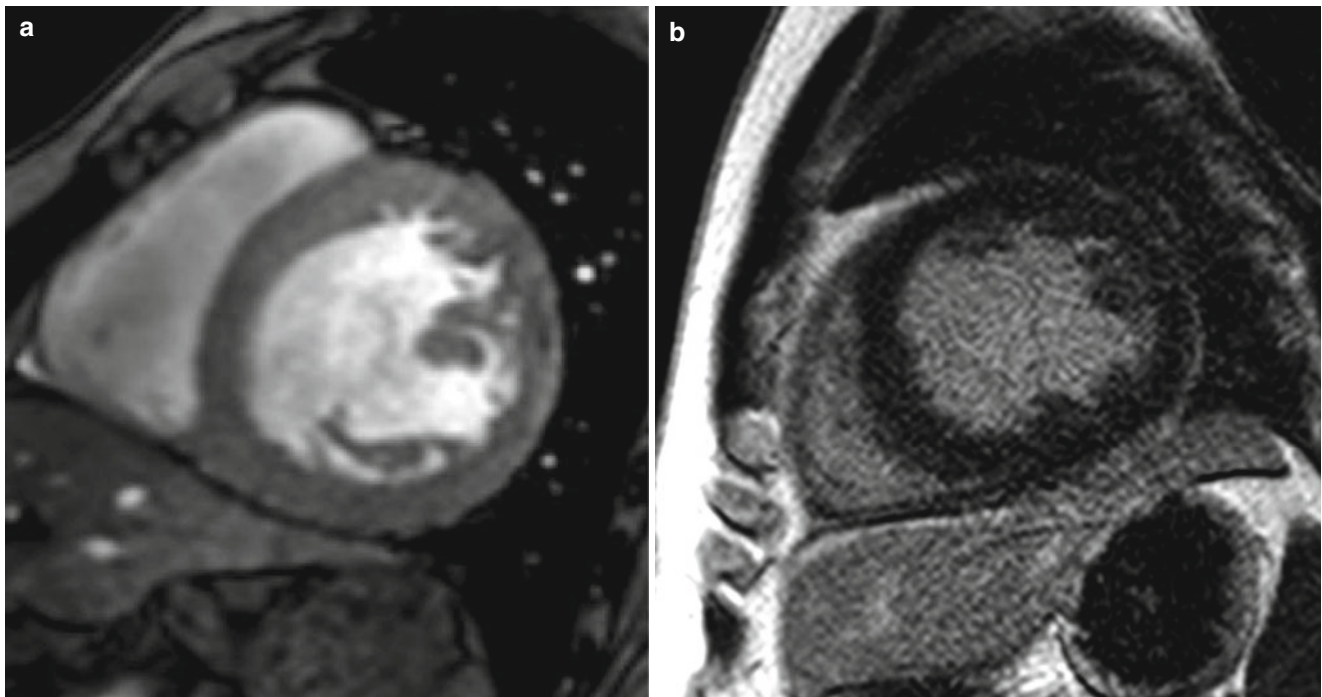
MRI of a patient with a history of excessive alcohol consumption. Invasive coronary angiographic findings were normal (not shown here). (a) Short-axis cine MRI shows a dilated left ventricle.
